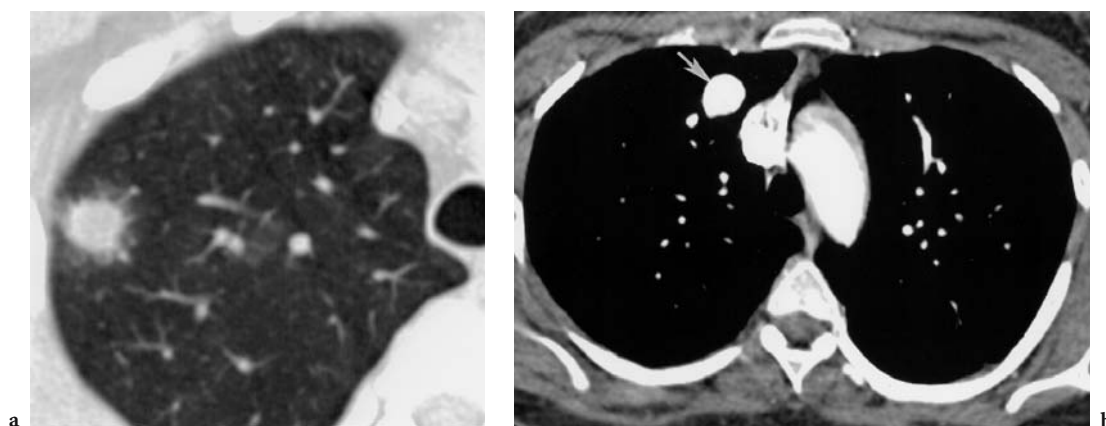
Pulmonary nodules. a: Invasive aspergillosis. CT scan at lung window setting shows a well-circumscribed nodule surrounded by hazy opaque infiltrate (halo sign) in the right upper lobe. b: Arteriovenous malformation. CT scan shown at soft-tissue setting shows a well-circumscribed enhancing nodule (arrow) in the right upper lobe
